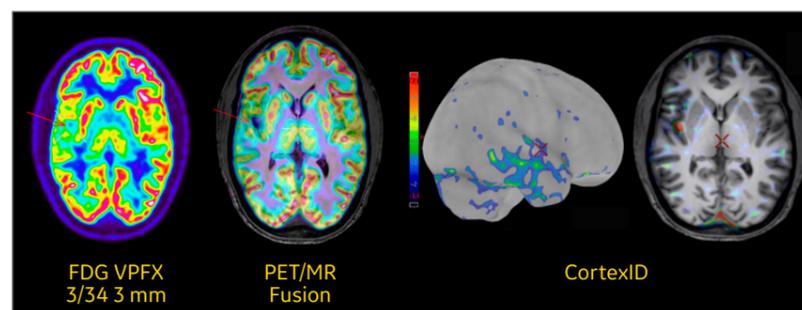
Patient with therapy-resistant epilepsy and no lesion on MRI where FDG PET imaging was used to plan the surgical procedure.
